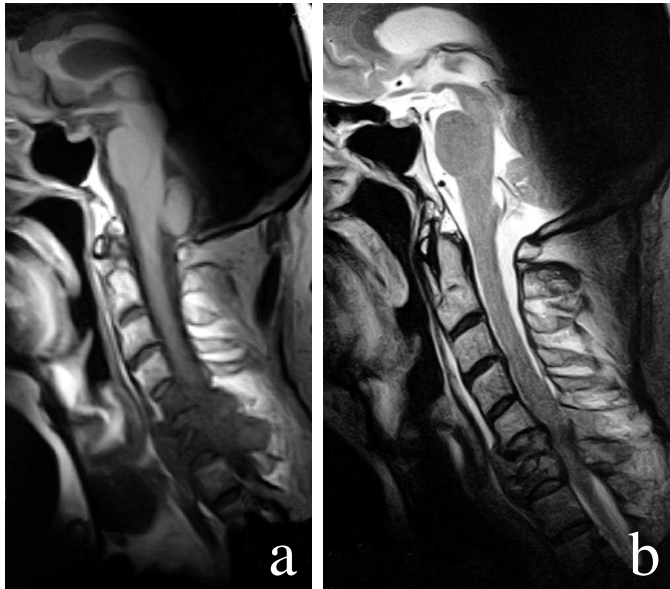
Sagittal T1-weighted SE (TR/TE, 650/15) (a) and T2-weighted TSE (TR/TE, 3590/100) (b) images show involvement of the vertebrae and compression of the spinal cord.
